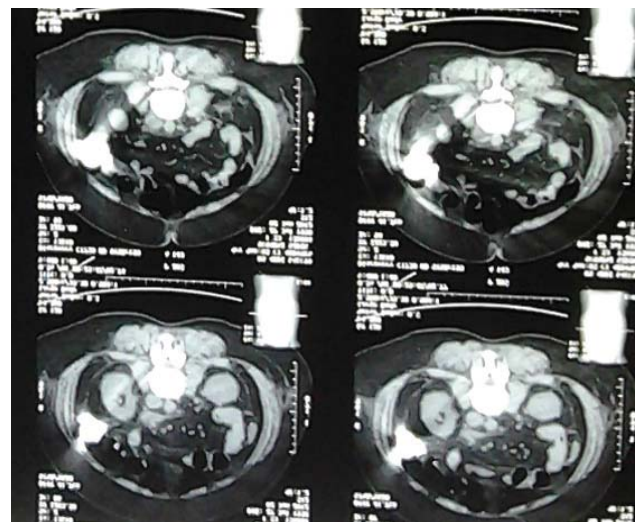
CT scan abdomen found no abnormalities
